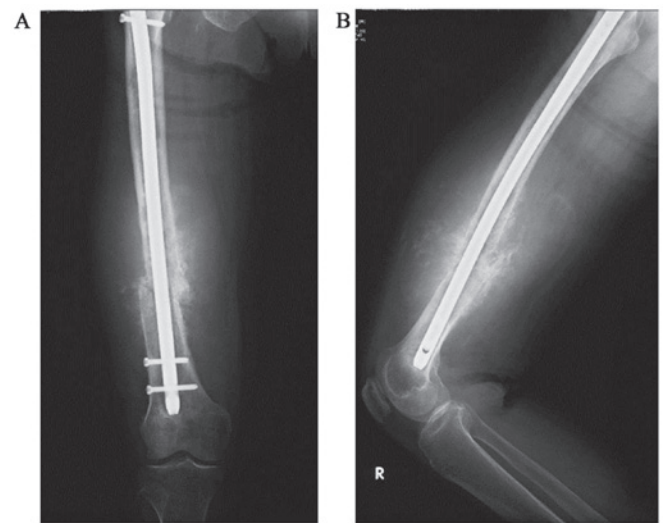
Radiographs obtained 6 months after the original surgery. A total of 6 months after the initial fracture, the patient visited Hirosaki University Hospital (Hirosaki, Japan) with abnormal swelling of the right thigh and limited range of motion in the right knee. Plain radiographs revealed incomplete bone union of the right femoral diaphyseal fracture, and a periosteal reaction with a sunburst-like appearance around the fracture. (A) Front view. (B) Side view.
